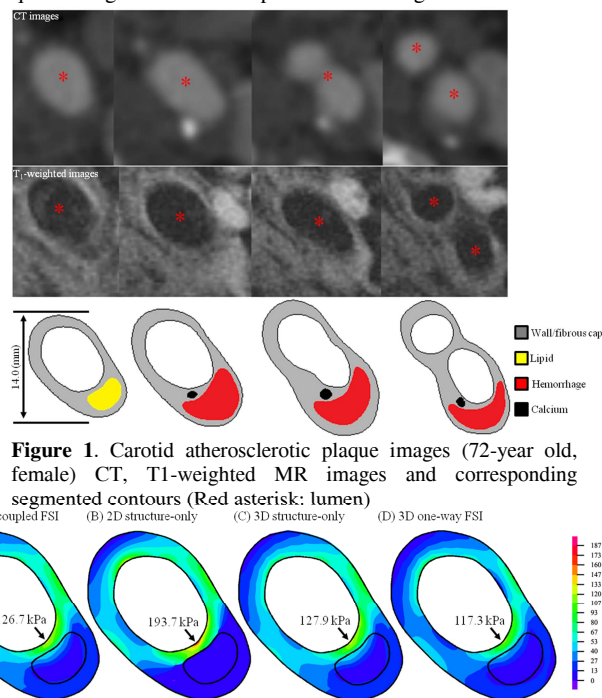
Carotid atherosclerotic plaque images (72-year old, female) CT, T1-weighted MR images and corresponding segmented contours (Red asterisk: lumen)
